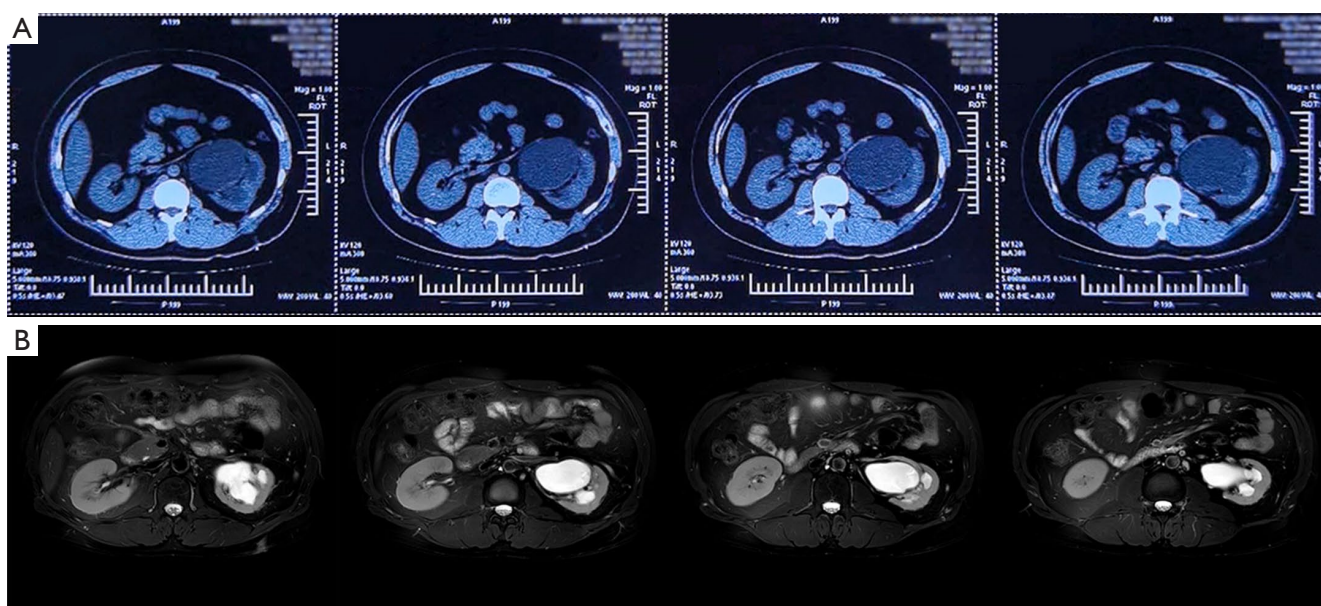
Radiographic evaluation. (A) Preoperative computed tomography urography. (B) Postoperative magnetic resonance urography.
